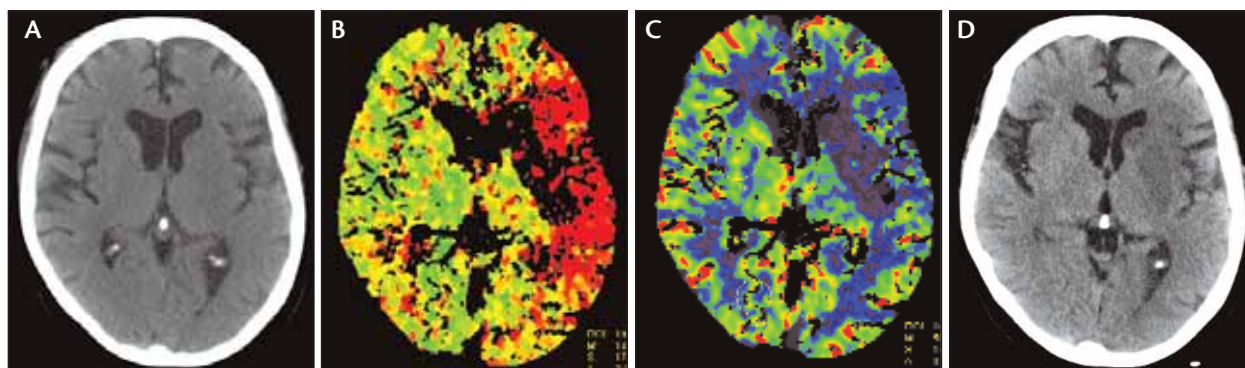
Case study: 77-year-old female patient with acute onset of dense right upper extremity paralysis and lower extremity weakness. Stuttering onset of symptoms 7 hours before presentation. CT without contrast axial slice at the level of the foramen of Monro, communication between the lateral and third ventricle (A). There is no evidence of intracranial hemorrhage or obvious infarction. TTP image shows the decrease in density in the left middle cerebral artery distribution (B). CTP image showing diminished CBV (C). The dark blue area indicates an ischemic core in the subcortical white matter of the left hemisphere. The previous CT without contrast did not display this ischemic core. CT without contrast the next day (D). The ischemic core predicted by CT perfusion images can now be seen in the caudate, putamen, and a portion of the subcortical white matter beneath the insula. This region was seen at the time of presentation in the CTP but not in the CT without contrast (Somatom Sensation 64-slice CT scanner).
